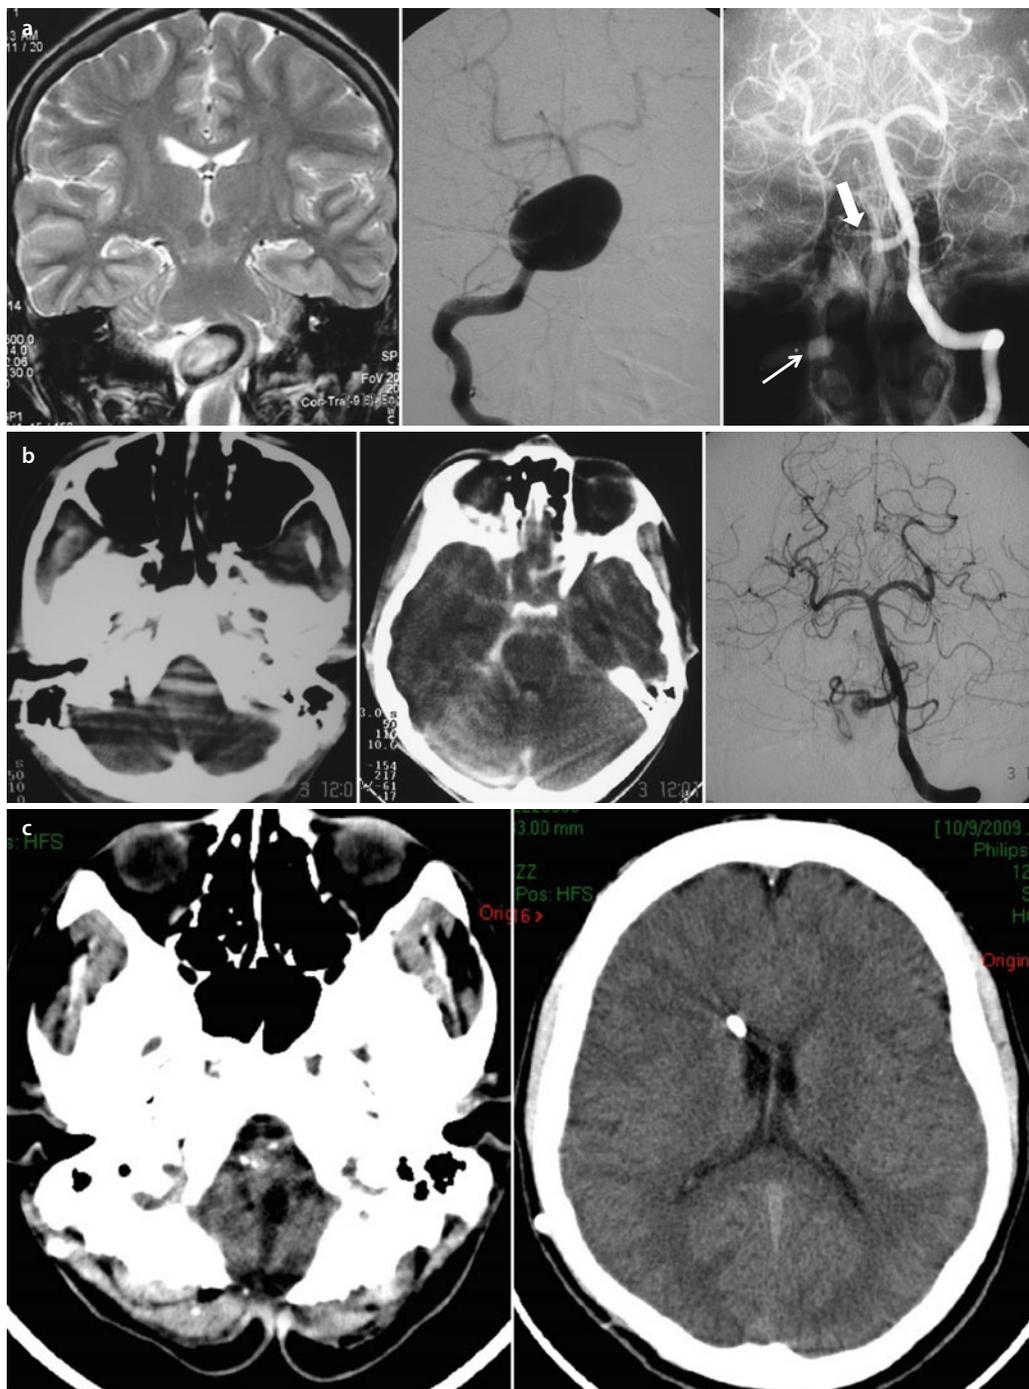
A 17-year-old man presented with clinical features of brainstem compression. (a) On February 2004, coronal T2 W MRI and cerebral DSA reveal a 28 × 16 mm-sized right V4 GIA causing brainstem compression. There is no intra-aneurysmal thrombosis. On July 2004, the patient was treated with PVO of the right vertebral artery using detachable balloons (*arrows*). Postprocedural DSA reveals flow reversal in the right vertebral distal V4 segment opacifying PICA that is incorporated into the aneurysm (*block arrow*). (b) After a month, the patient presented with acute posterior fossa SAH. Note that the patient was not on any antiplatelets or anticoagulants at the time. Cerebral DSA reveals filling of the PICA and distal portion of the aneurysm via flow reversal from the left vertebral artery. The patient was managed with posterior fossa decompressive craniectomy and ventriculo-peritoneal shunt placement. (c) After 5 years, the patient had moderate residual disability
